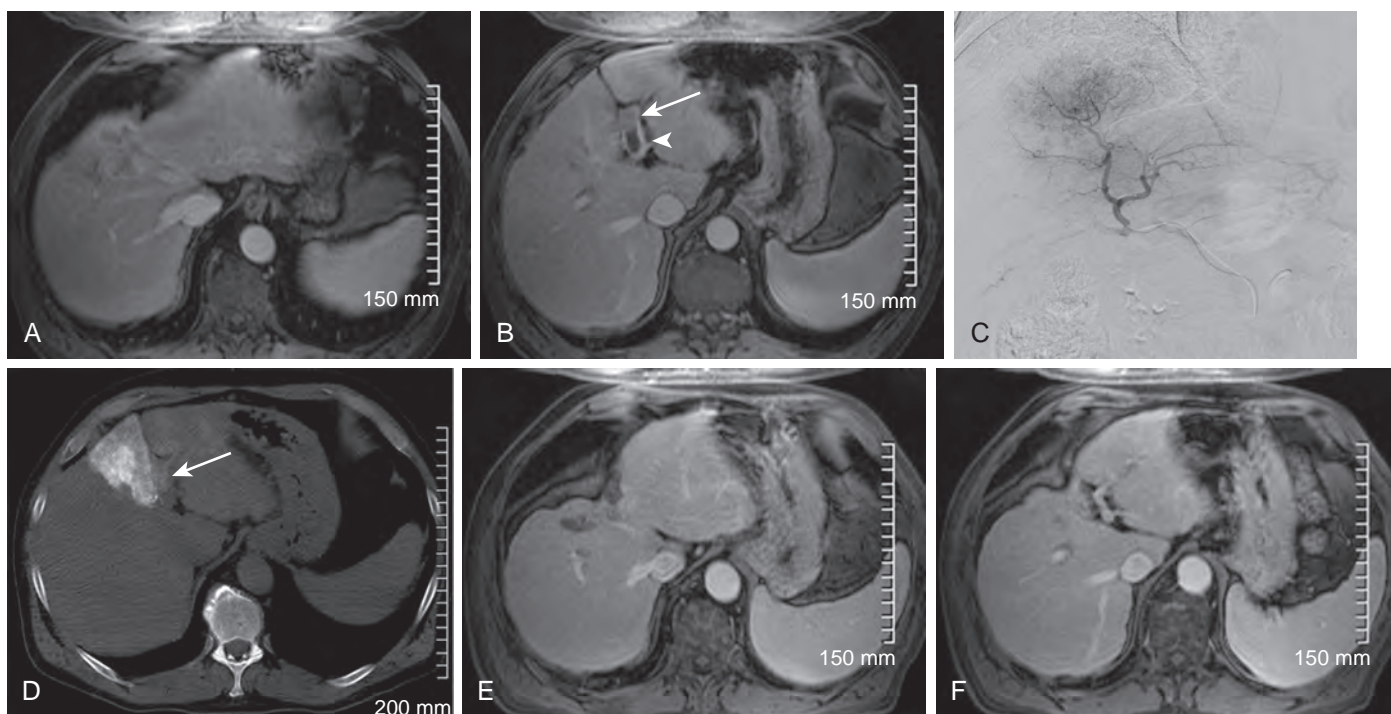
HCC with tumor thrombus treated with ⁹⁰Y transarterial radioembolization. A and B. Portal venous phase MRI demonstrates an infiltrative lesion with central portal venous washout and rim enhancement. Enhancing tumor thrombus (arrow) as well as nonenhancing bland thrombus (arrowhead) is identified in the left main portal vein. C. Selective left hepatic angiography demonstrates a hypervascular mass in segment IV. D. Intraprocedural CT after direct injection of iodinated contrast material into the left hepatic artery confirms tumor thrombus (arrow) in the left main portal vein. ⁹⁰Y glass microspheres were administered into the left hepatic artery. E and F. Portal venous phase imaging 3 years after ⁹⁰Y injection demonstrates complete response to therapy, changes of radiation segmentectomy, and a widely patent left portal vein.
